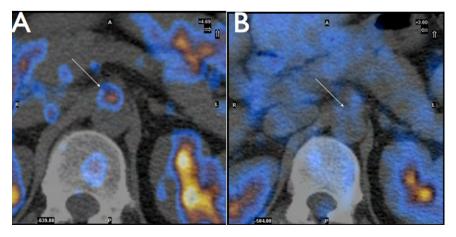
Fused PET/CT axial images showing (A) focal ¹⁸F-FDG uptake in the abdominal aortic wall (arrow), which has diminished with 3 months (B). There is no arterial calcification on the CT.
